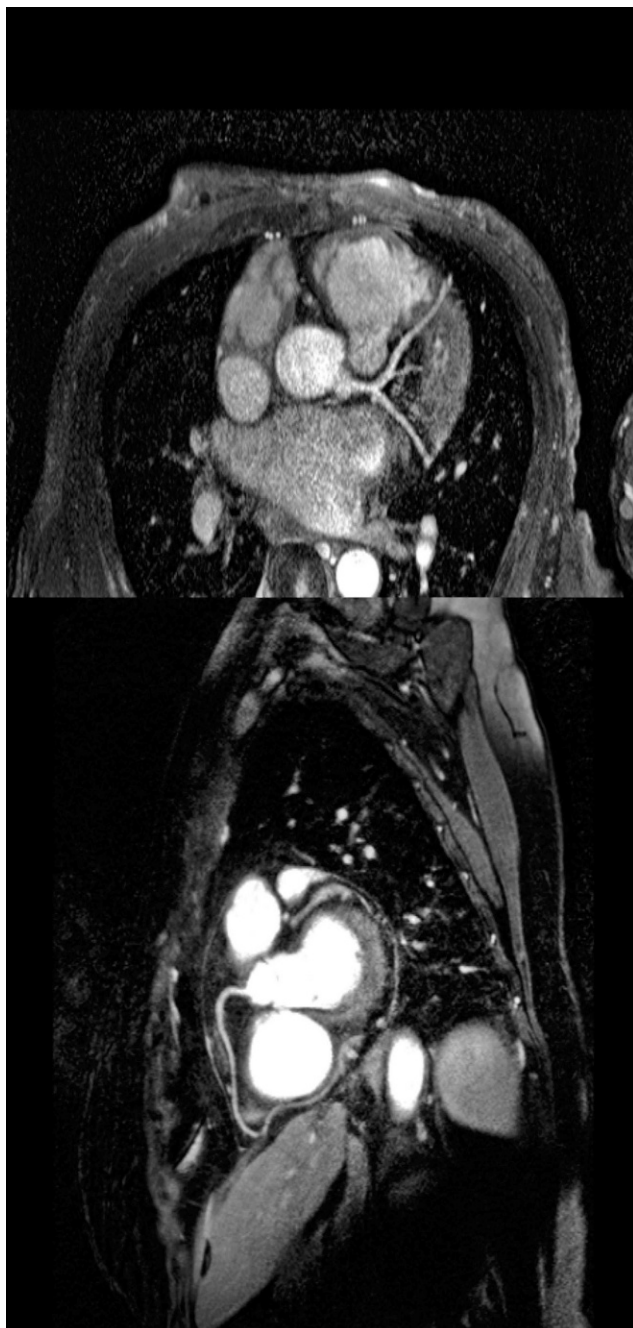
Case: 25-year-old female with chest pains. Cardiac magnetic resonance imaging: Bright blood images with navigation pulse. Diagnosis: Normal take-off of the left main (top) and right coronary artery (bottom).
